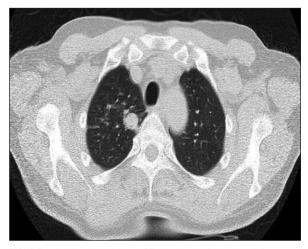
Axial section of thorax CT showing a pulmonary nodule.
